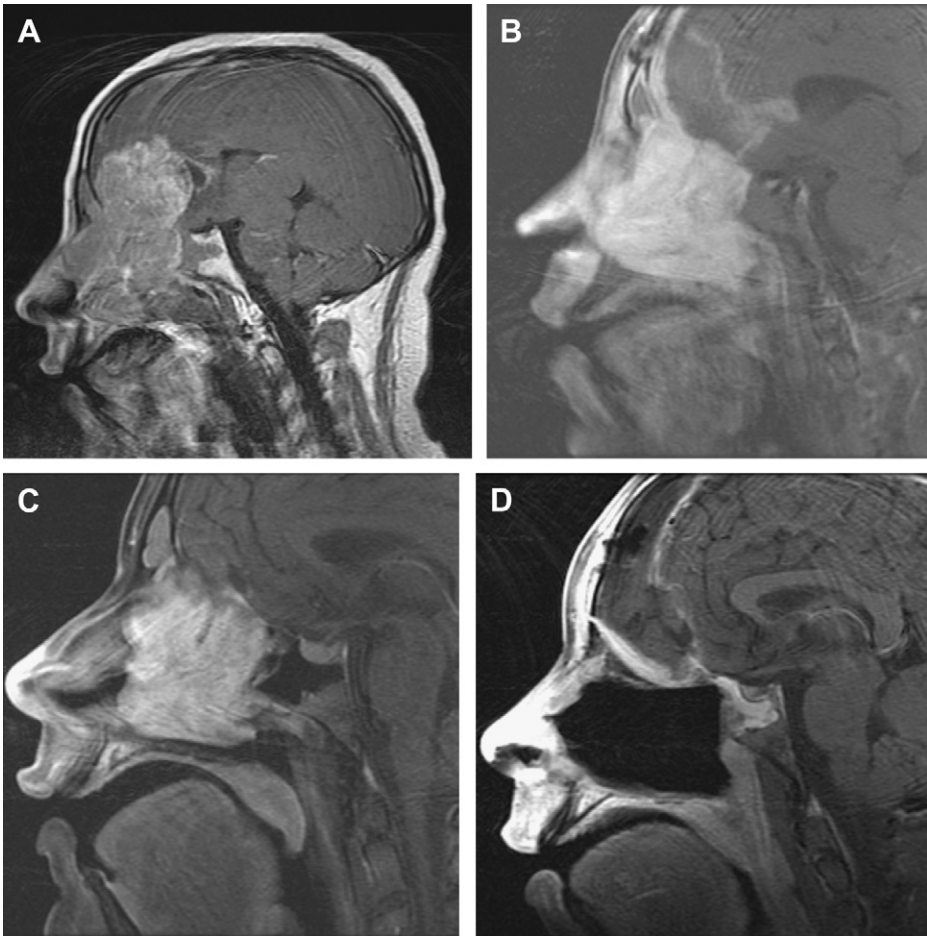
This 23-year-old man presented with acute obtundation and headache. Computed tomography imaging revealed a large frontal tumor with intracerebral hematoma. Initial sagittal postcontrast T1-weighted magnetic resonance imaging (MRI) (A) revealed a large sinonasal tumor with intracerebral extension. The patient was taken to the operating room emergently, and underwent resection of all intracranial tumor and evacuation of hematoma. (B) Postoperative sagittal postcontrast T1-weighted MRI. Pathology was consistent with sinonasal undifferentiated carcinoma. He was subsequently treated with 4 cycles of cisplatin and etoposide with partial response evident on the post-chemotherapy sagittal postcontrast T1-weighted MRI (C). He then underwent formal anterior craniofacial resection. The postoperative sagittal postcontrast T1-weighted MRI (D) confirmed complete tumor removal. Extensive pathologic analysis could not identify any viable tumor. He was treated postoperatively with intensity-modulated radiation therapy to a dose of 60 Gy in 30 fractions. He is free of disease 3 years later. (Courtesy of Department of Neurosurgery, The University of Texas M.D. Anderson Cancer Center; with permission.)
